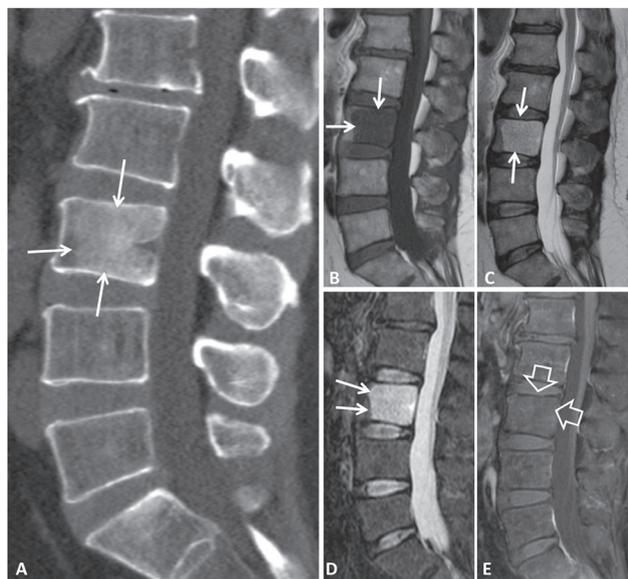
A 58-year-old male patient with mechanical low back pain over the last 2 months. Sagittal CT reconstruction (A) showing an osteosclerotic L3 vertebra with diffuse osteosclerosis (arrows). Other causes for this appearance include metastatic deposits from breast or prostatic carcinoma and Paget's disease. Sagittal T1w (B) and T2w (C) MR images show a low and high signal intensity lesion respectively, which might correspond to osseous haemangioma (arrows). The high signal intensity on STIR (arrows in D) is not compatible with a haemangioma. Sagittal fat suppressed contrast enhanced T1w (E) MR image shows no enhancement (open arrows). The findings are suggestive of a benign notochordal cell tumour which did not show any deterioration within a 5-year imaging follow up.
